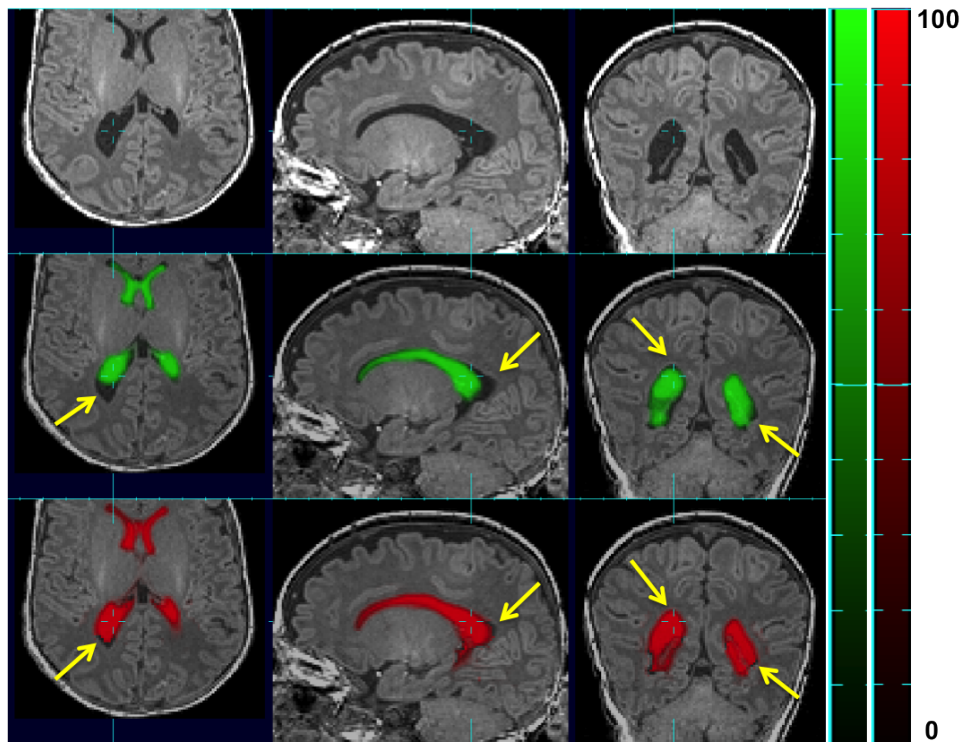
Raw MR image overlaid (top row) with atlas-based tissue probability map (SA-TPM) (middle row) and patch-based (bottom row) tissue probability map of VENT in one subject with ventriculomegaly. Tissue probability is on a scale of 0 - 100. Yellow arrows point where patch-based TP is more accurate than atlas-based one.
